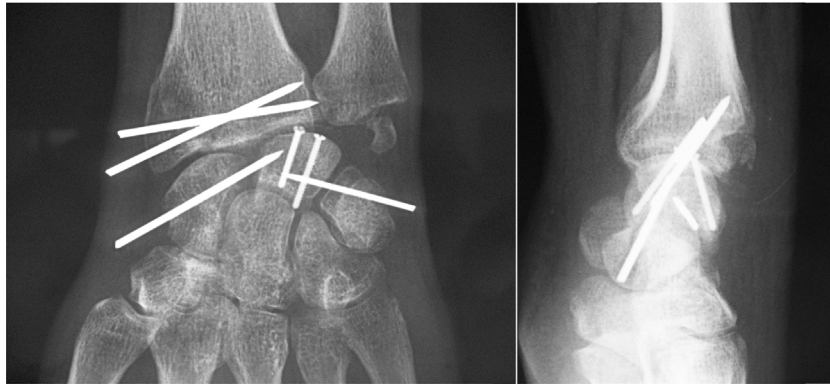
Standard intraoperative A/P and lateral radiographs of the left wrist.
